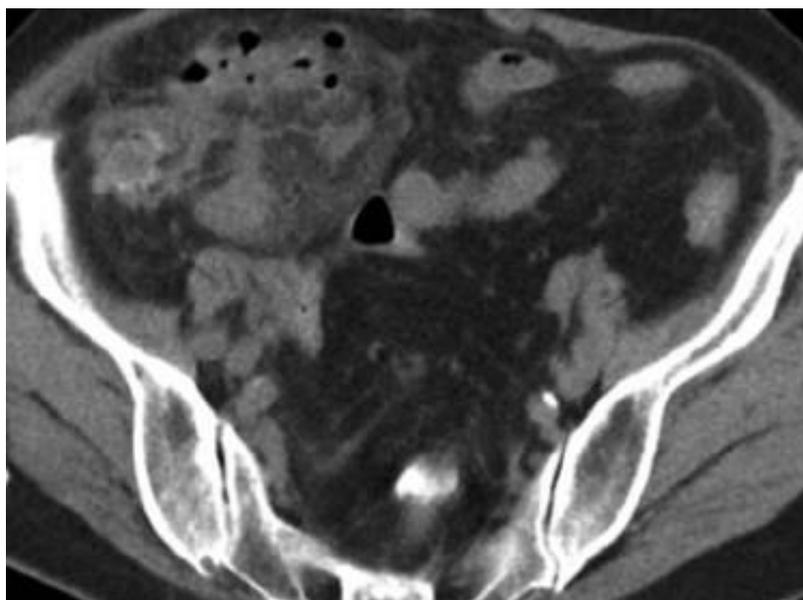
Axial CT showing perforated ileal diverticulitis (32)
